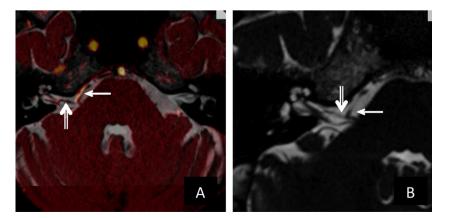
Right-sided primary hemifacial spasm caused by loop of an antero-inferior cerebellar artery (AICA) (arrow) at level of the pontocerebellar trigone arachnoidal cistern (double arrow), as shown in A (axial reformatted images obtained by fusion of 3D-T2-weighted CISS) and TOF angiography sequences) and B (axial 3D-T2-weighted CISS sequence).
